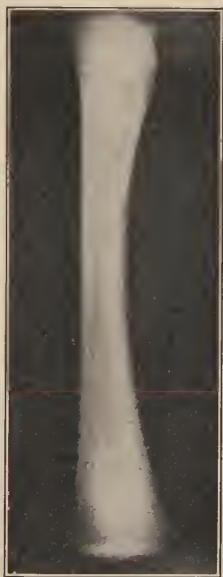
X-ray photograph of normal bone.
